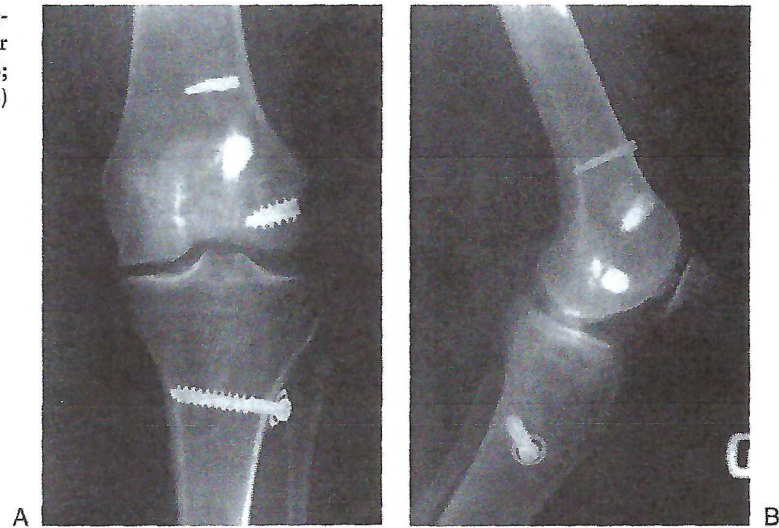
Fourteen months after reduction and reconstruction with hinge application, the anteroposterior radiograph (A) reveals symmetric reduction with a slight reduction in the medial joint space. Comparison lateral radiographs reveal symmetric centering of the joint with the tibia slightly anterior to the femur at 90° of flexion between the injured (B) and noninjured (C) knees. (From Ref. 17, by permission of *Sports Medicine and Arthroscopy Review*.)
